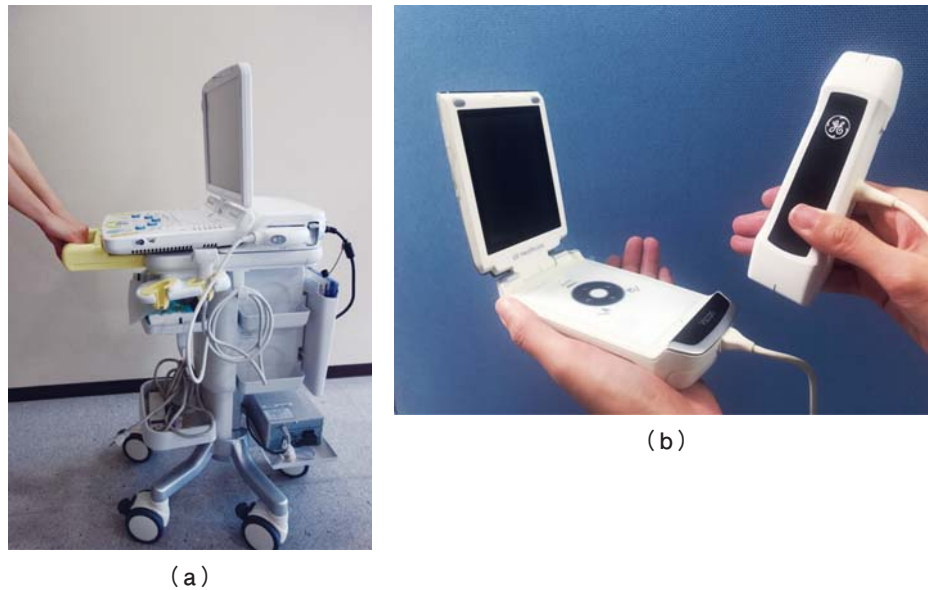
Portable ultrasound device (Noblus) (a) and hand-held ultrasound device (Vscan Dual Probe) (b).
